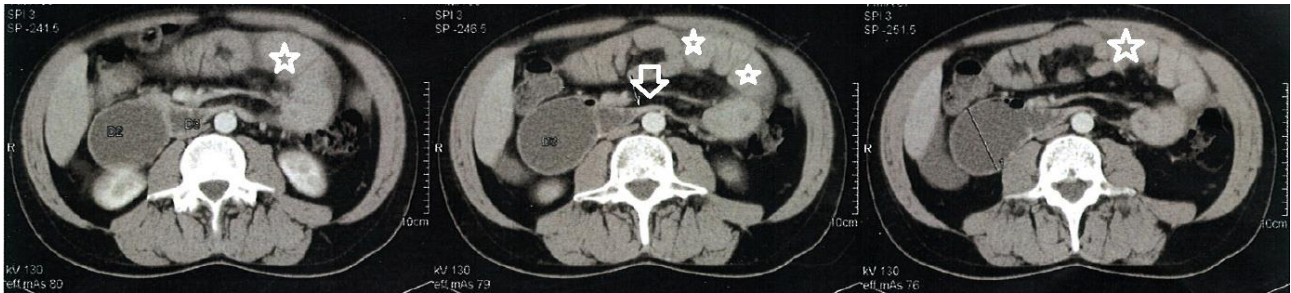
axial sections of the CT scan of our patient, acquisition after digestive marking and after injection of iodinated contrast product; we demonstrate the presence of a pseudo sac made of agglutinate of hail loops (white star).
